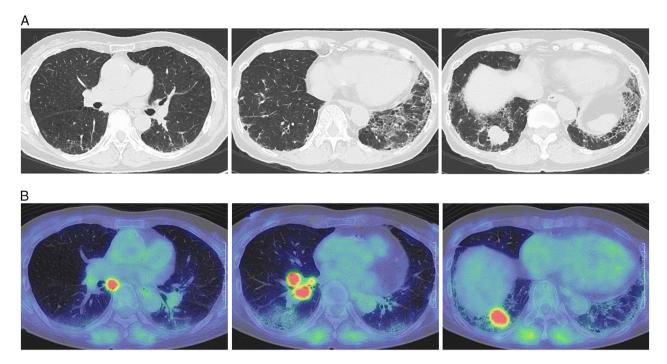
Images of (A) computed tomography (CT) of the chest and (B) ¹⁸F-FDG positron emission tomography/CT prior to chemotherapy.
